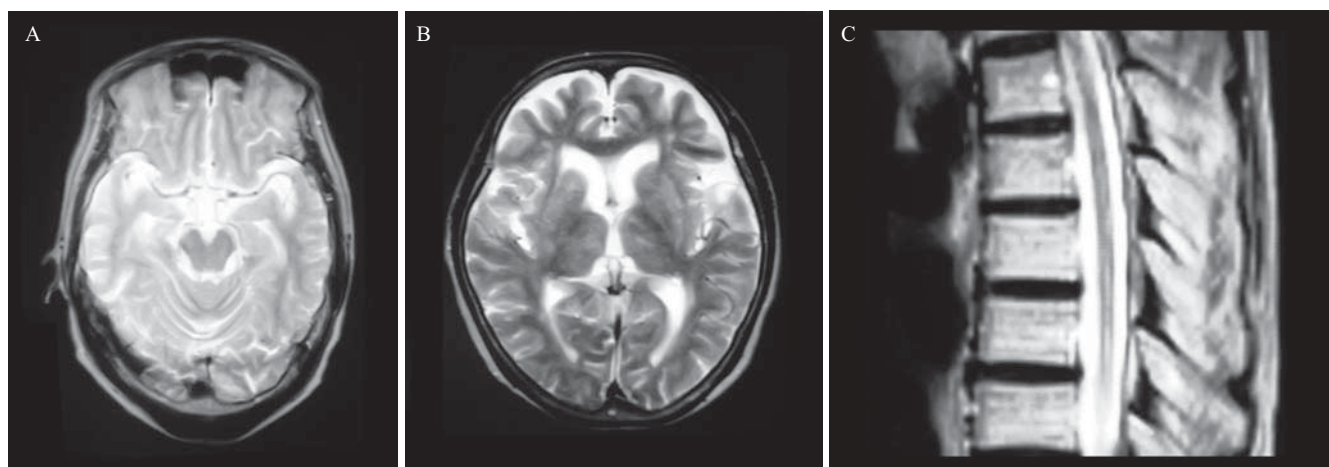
Representative T2-weighted images from head and spine magnetic resonance imaging. Scans performed on Case 3 (a), Case 2 (b, c) did not reveal any significant intracranial or spinal lesions associated with myoclonus
